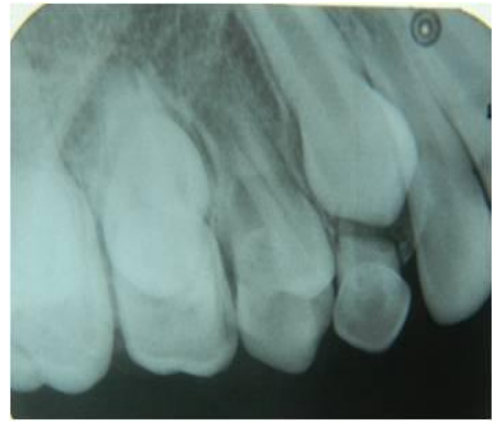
Intra oral periapical radiograph showed a pericoronal shadow of soft tissue covering the erupting tooth
